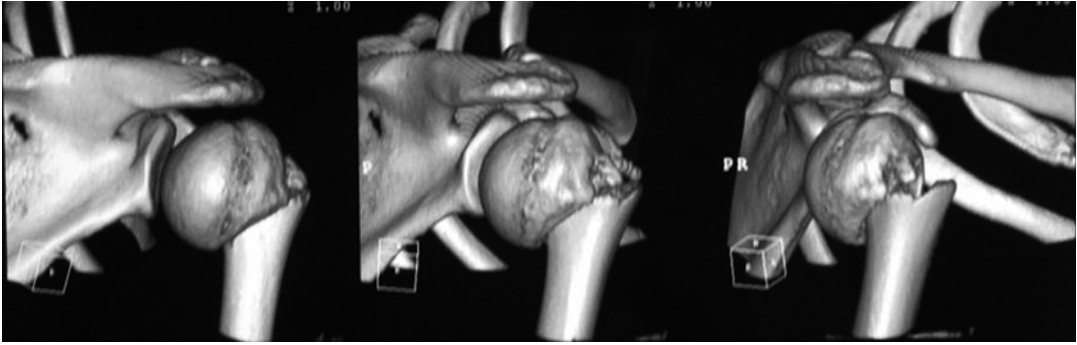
3D CT scan helps us to plan the reduction maneuvers needed to realign the diaphysis. They must neutralize the force vectors of the pectoralis major
